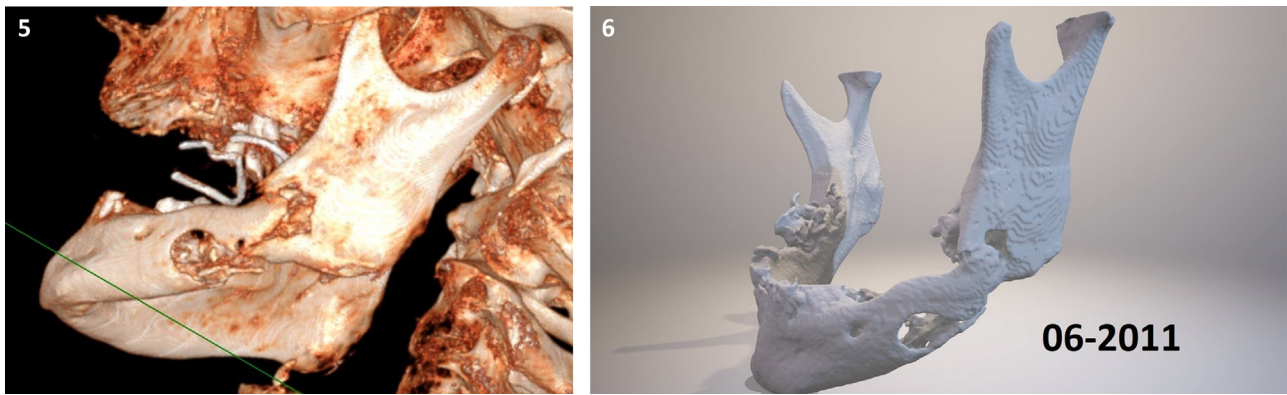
3D CT at the same time.
